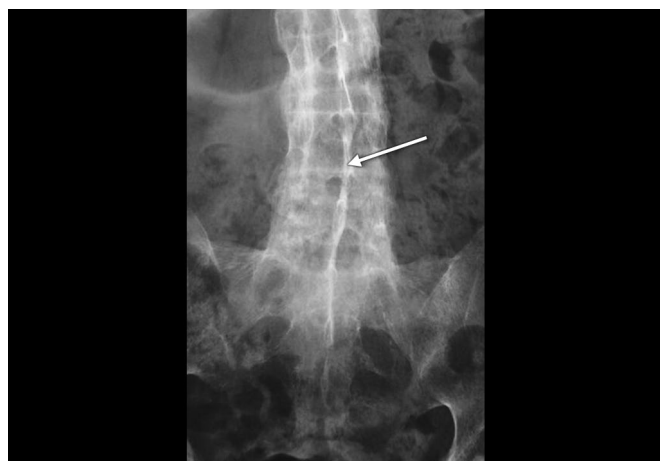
AP X-ray of LS spine showing a central radiodense line due to ossification of interspinous and supraspinous ligaments.
